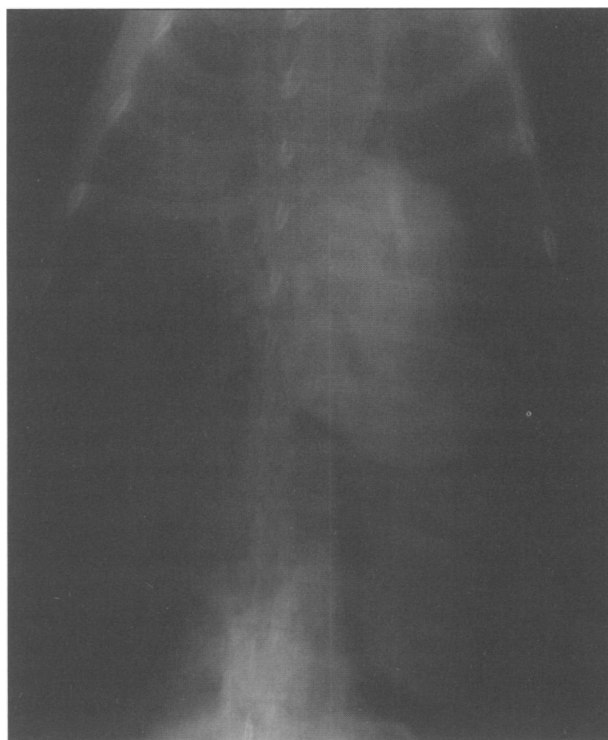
Thoracic radiographs of a clinically normal border collie with no history of trauma that developed cyanosis and hypoxia during routine ovariohysterectomy. Gas-filled loops of bowel are evident in the thorax.
